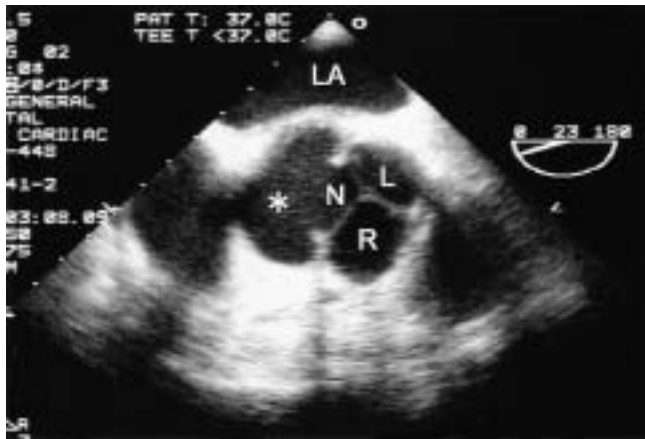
Transesophageal basal short-axis echocardiogram at the level of the Freestyle bioprosthesis, showing the false aneurysm (\*) and perforation of the non-coronary sinus of the bioprosthesis.
